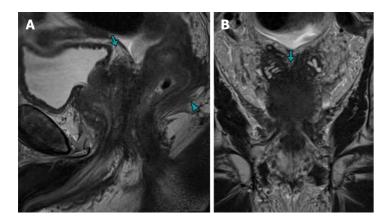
Magnetic resonance imaging images of case 1 demonstrating advanced prostate adenocarcinoma with rectal involvement. A and B: The sagittal (A) and Coronal (B) T2 turbo spin echo images reveal diffuse neoplastic involvement of the prostatic parenchyma, with extension into the rectal wall (arrowhead) and base of the seminal vesicles (arrow).
